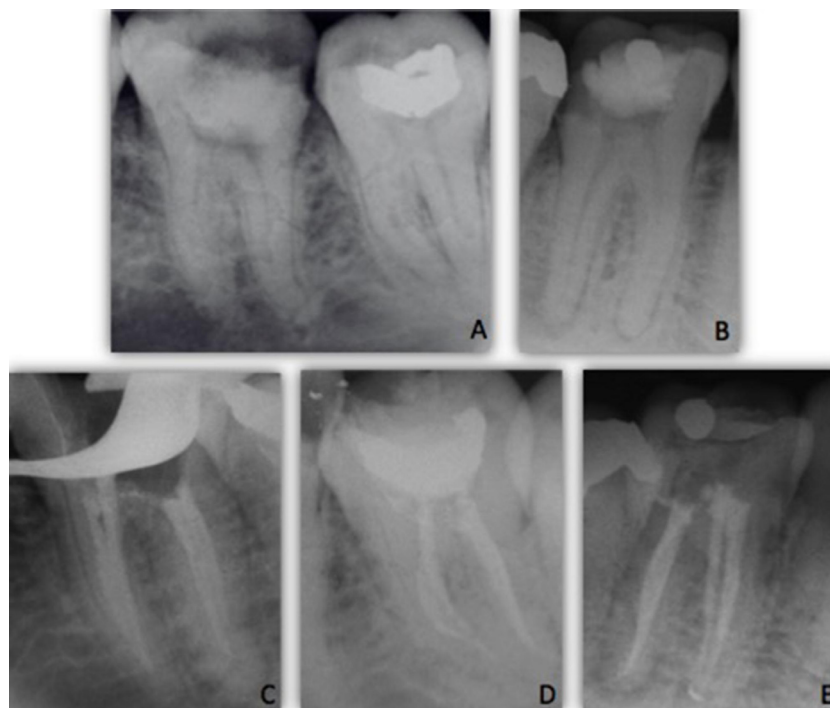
A) Initial radiograph of teeth #36 and #37; B) Initial radiograph of tooth #46; C) Final radiograph of tooth #36; D) Final radiograph of tooth #37; E) Final radiograph of tooth #46
